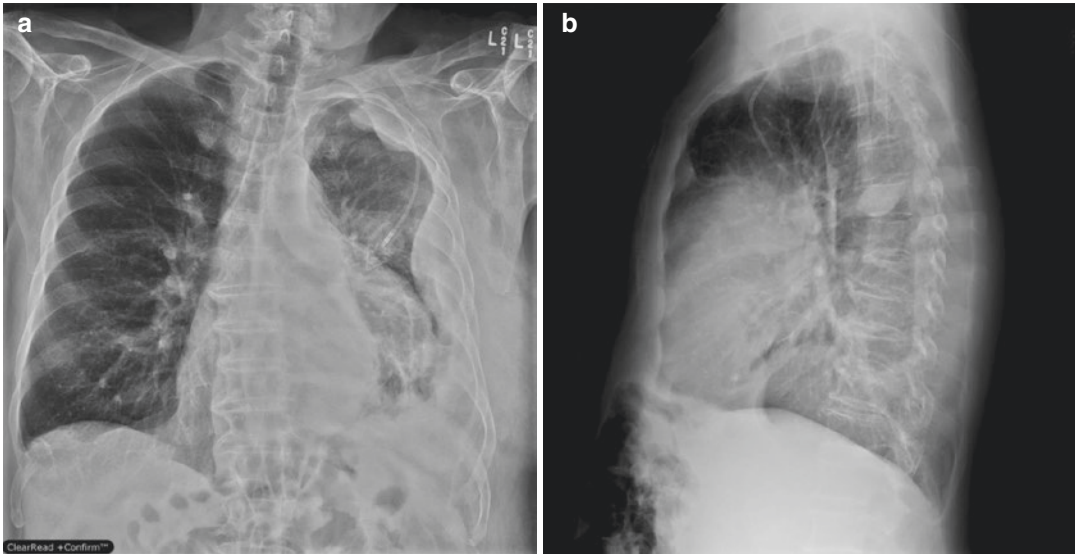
(a) Posteroanterior (b) and lateral chest radiographs of a patient with left-sided malignant pleural mesothelioma. Note unilateral irregular pleural thickening
